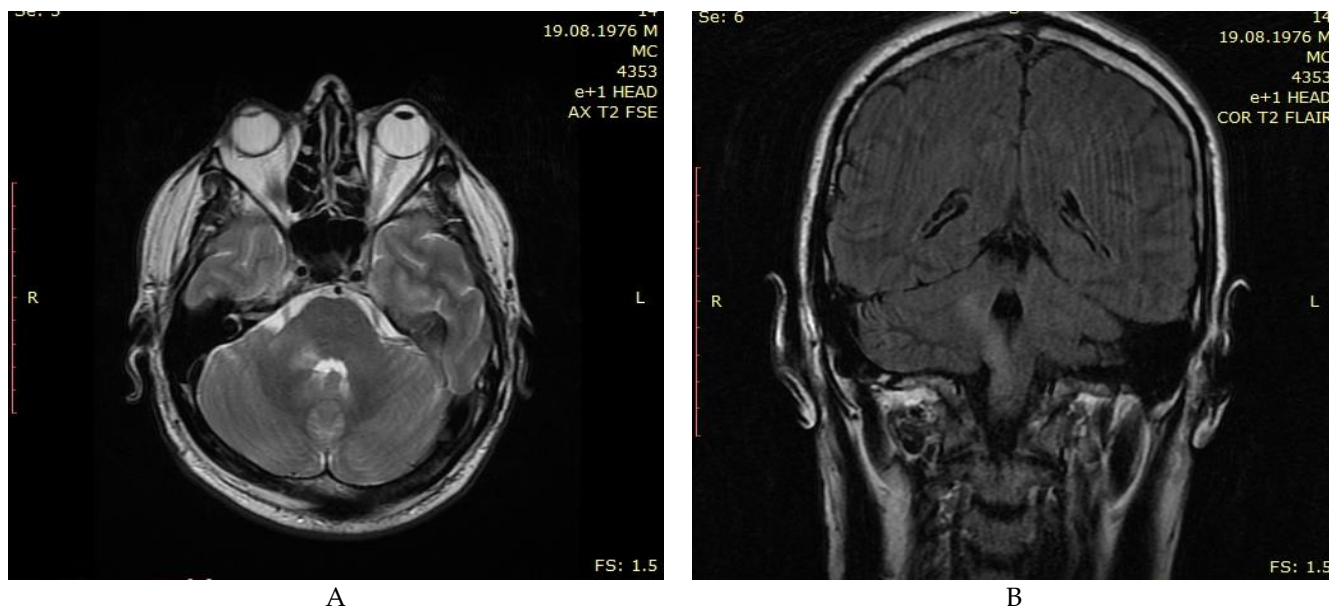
MRI of the patient's brain, July 29, 2021: a) axial sections in T2 weighted image; B) frontal sections in FLAIR sequence. The area of damage in the medulla oblongata, pons, and right middle cerebellar peduncle
